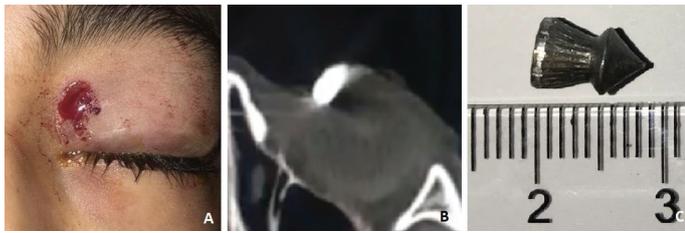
Case 7. A) Wound in the upper eyelid B) Computed Tomography image of the foreign body in the upper eyelid C) Air-gun pellet
